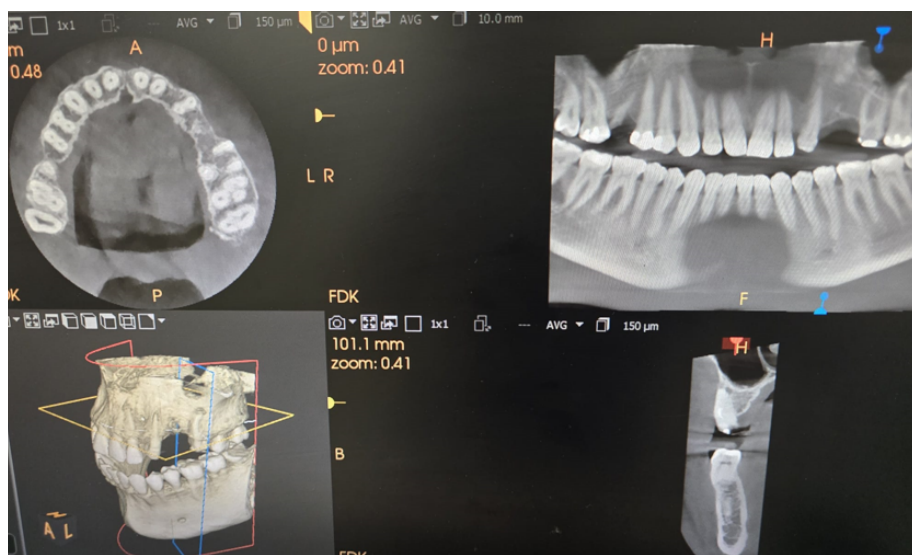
CBCT performed after dental bridge removal.
